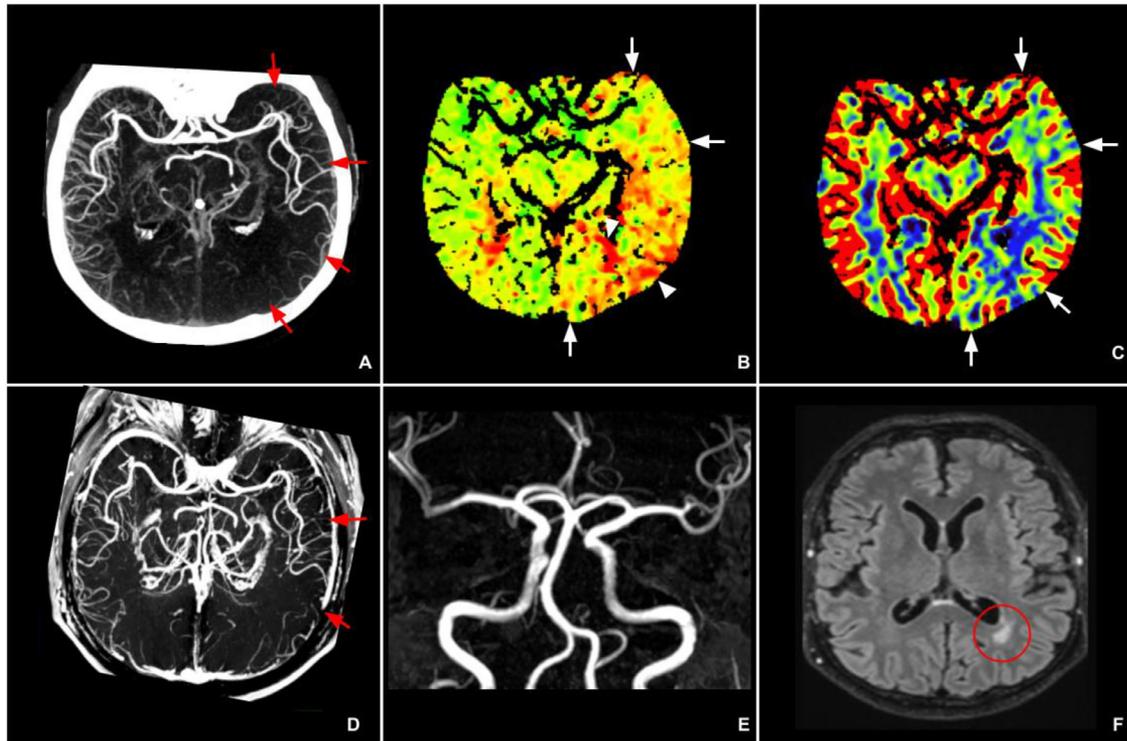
(– A) CTA - maximum intensity projection: marked paucity of left MCA and PCA leptomeningeal vessels (red arrows). (B) CTP - TTP: hypoperfusion of left MCA and PCA territories (white arrows), predominantly in the superficial watershed and the deep periventricular regions (white arrowheads). (C) CTP - CBV: moderate decrease in the corresponding areas (oligemia). (D) MRI - 3DT1-GE-Gd: leptomeningeal vascular paucity. (E) MRI - TOF: normal caliber of moderate-to-large intracranial arteries. (F) MRI - FLAIR: white matter hyperintensity focus in the deep left peritrigonal region.
